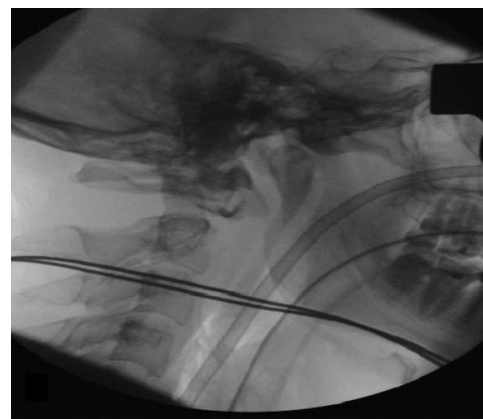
Pre-operative X-ray shows atlanto-axial dissociation.
